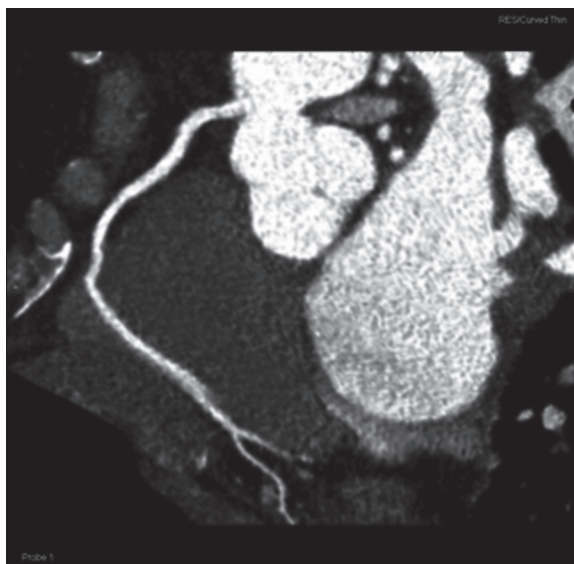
Cardiac CT. Curved multiplanar reformed (MPR) image shows the normal origin and intra-atrial course of the right coronary artery.
